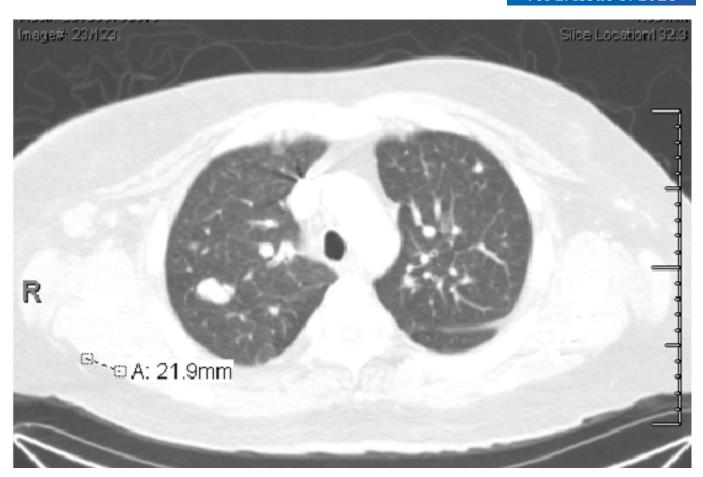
CT of the Chest
